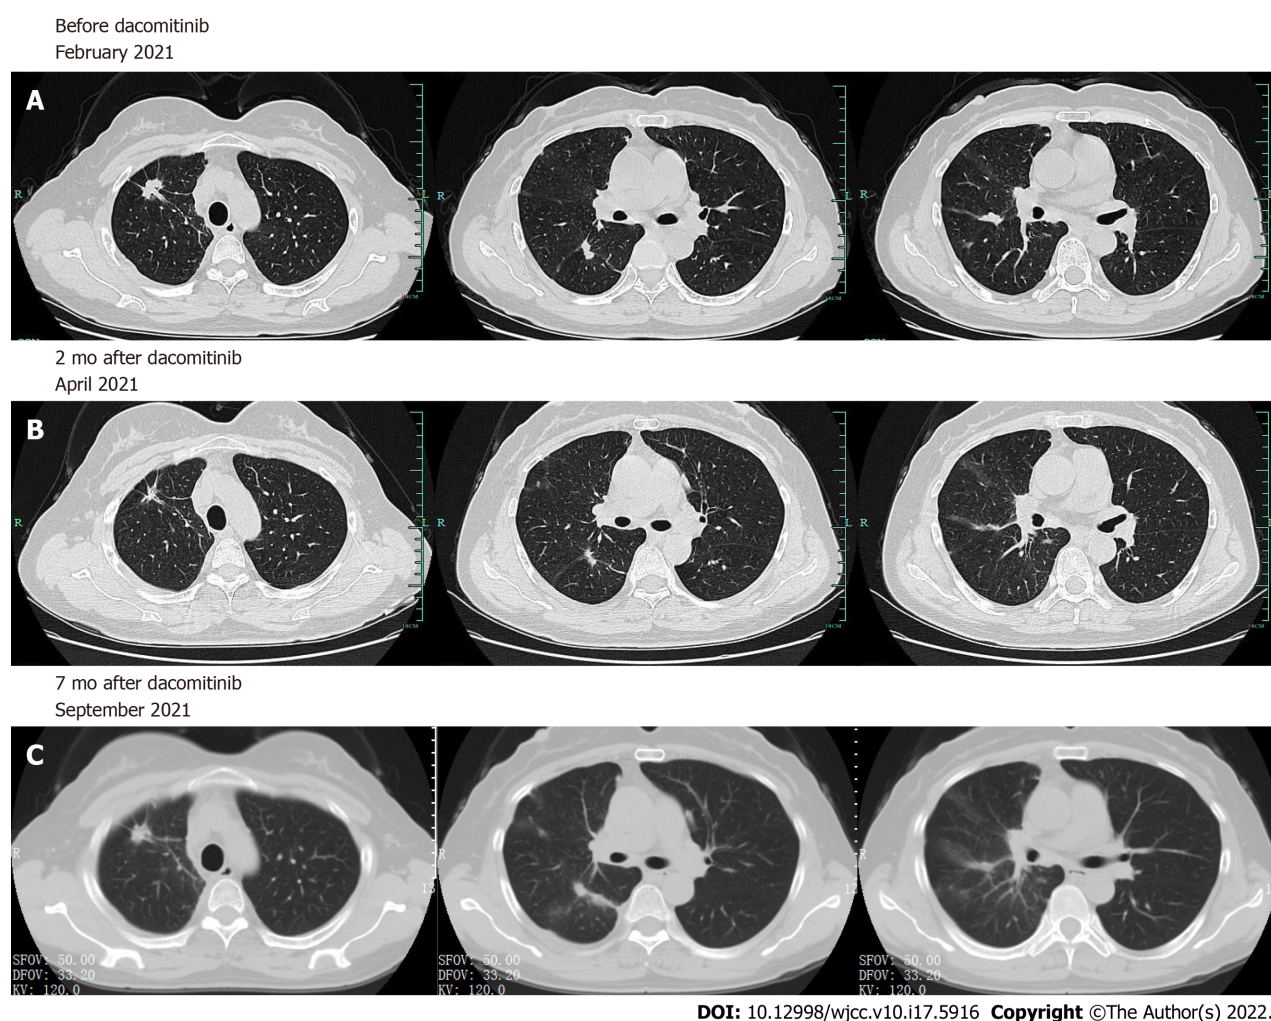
Chest computed tomography scans. A: Chest computed tomography scans before (A) and after dacomitinib therapy; B and C: The patient achieved partial response 2 mo after the initiation of dacomitinib therapy and progressed at 7 mo later.
